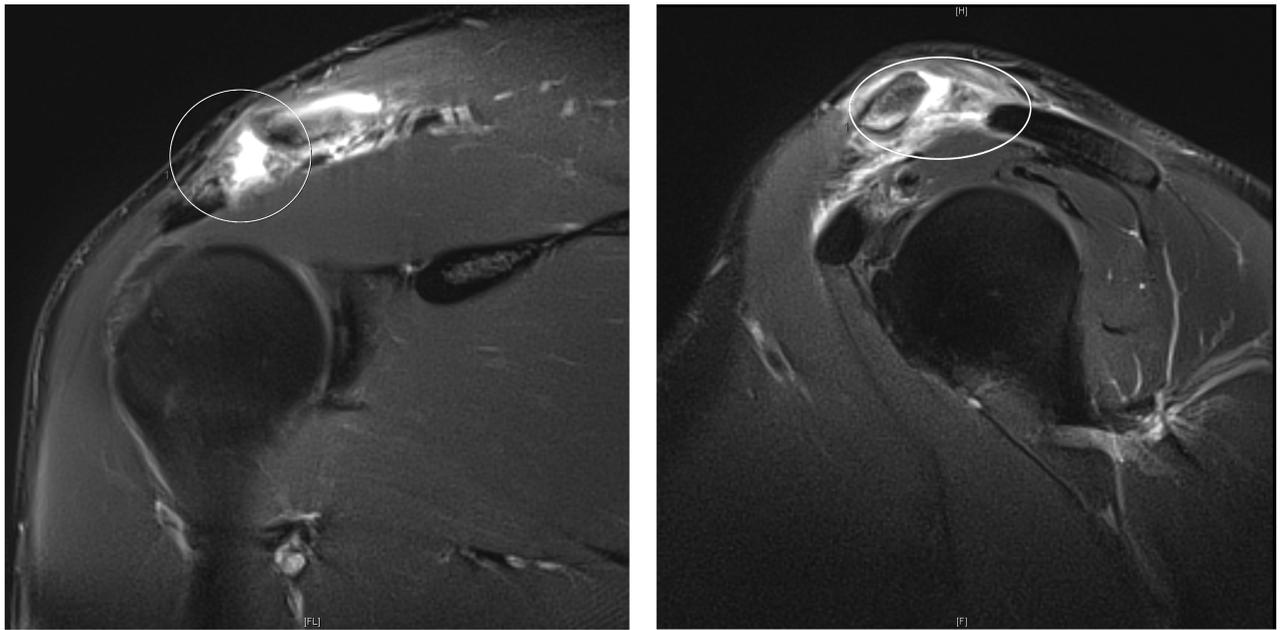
Magnetic resonance imaging—Coronal and sagittal T2-weighted images with fat suppression. Ellipse denotes acromioclavicular separation. There is complete disruption of the acromioclavicular ligament and coracoclavicular ligaments with surrounding edema (bright signal).
